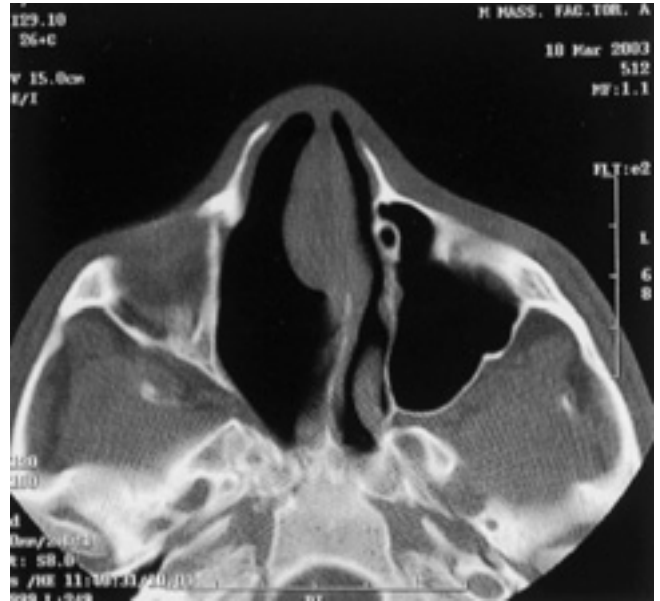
Axial CT scan 5 years after onset
